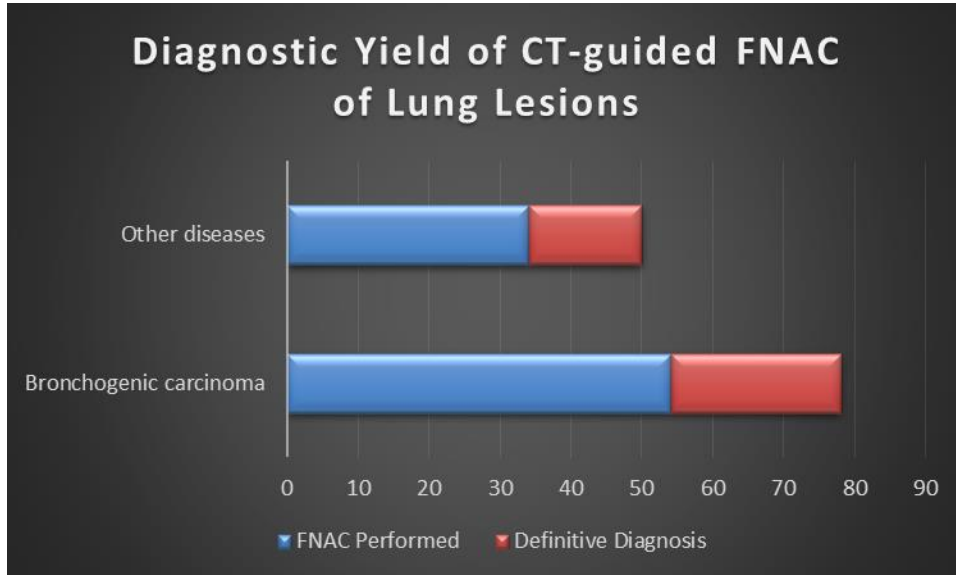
The diagnostic yield of CT-guided fine needle aspiration cytology is presented in figure 3.
